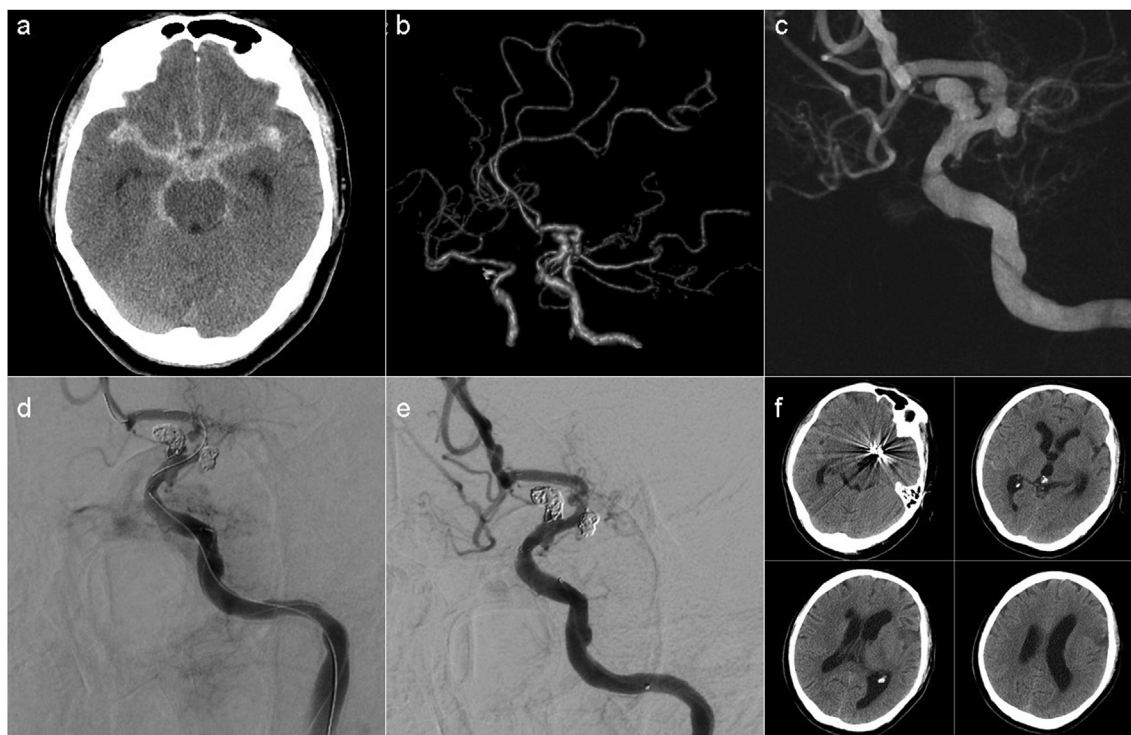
Images of Case 5. a and b: The emergency head CT showed subarachnoid hemorrhage with a Fisher score of 3, and the CT angiography found an aneurysm on the top of BA about 3.5 mm\*2.5 mm in size. c: The V4 segment of the left vertebral artery and the BA were not visualized anymore after the guiding catheter was placed. d: Despite the success of revascularization, severe vasospasm was seen in the BA after MT. e: The aneurysm was successfully treated with stent-assisted coiling and the vasospasm of the BA improved significantly. f: No obvious cerebral infarction was found in the head CT 5 days after the endovascular treatment.
